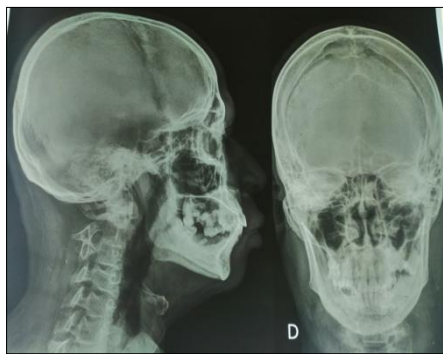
Radiographs of the skull (profile, face)
